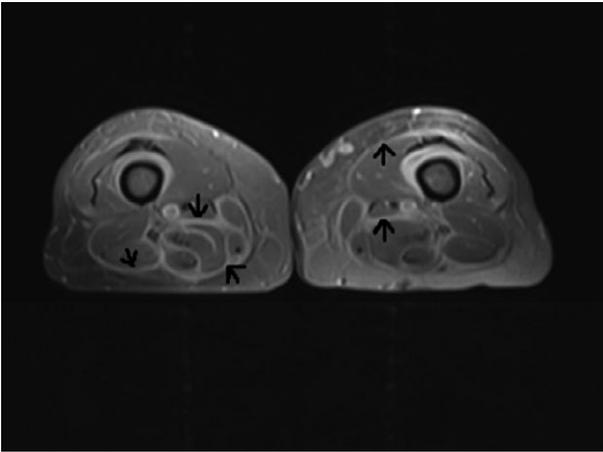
Axial T1-weighted post-contrast magnetic resonance imaging with fat-saturation obtained through the level of the mid-thighs. Abnormal diffuse thickening and enhancement of fascial planes is evident bilaterally, consistent with fasciitis. The closed arrows show the thick and enhanced fascia surrounding the muscles.
